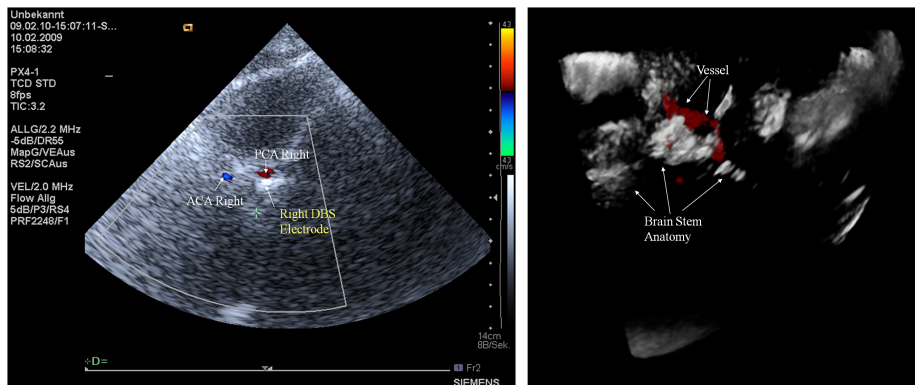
Transcranial ultrasound scans of the basal ganglia in 2D on patient 1 (left) and in 3D on patient 2 (right). The cross-section of the DBS electrode in relation to the PCA (arteria cerebri posterior) can be clearly seen in patient 1. The right image shows a 3D reconstruction of the brain stem anatomy of patient 2 (white) and the reconstructed PCA vessel (red).
